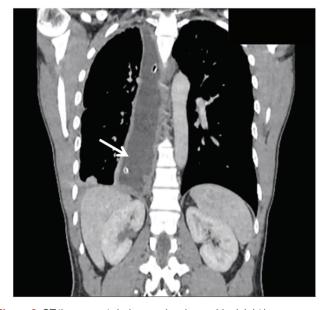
CT thorax post-drainage; showing residual right lung empyema with mega-esophagus
